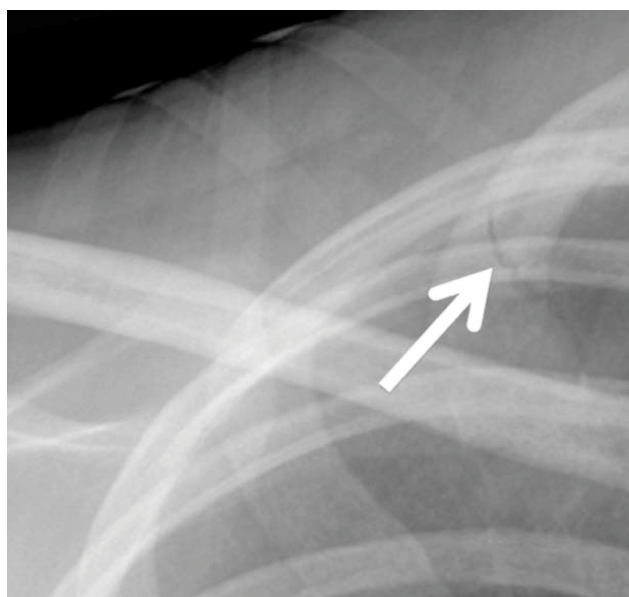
CT Scan of Right Upper Thorax with Arrow at Fracture of First Rib.
